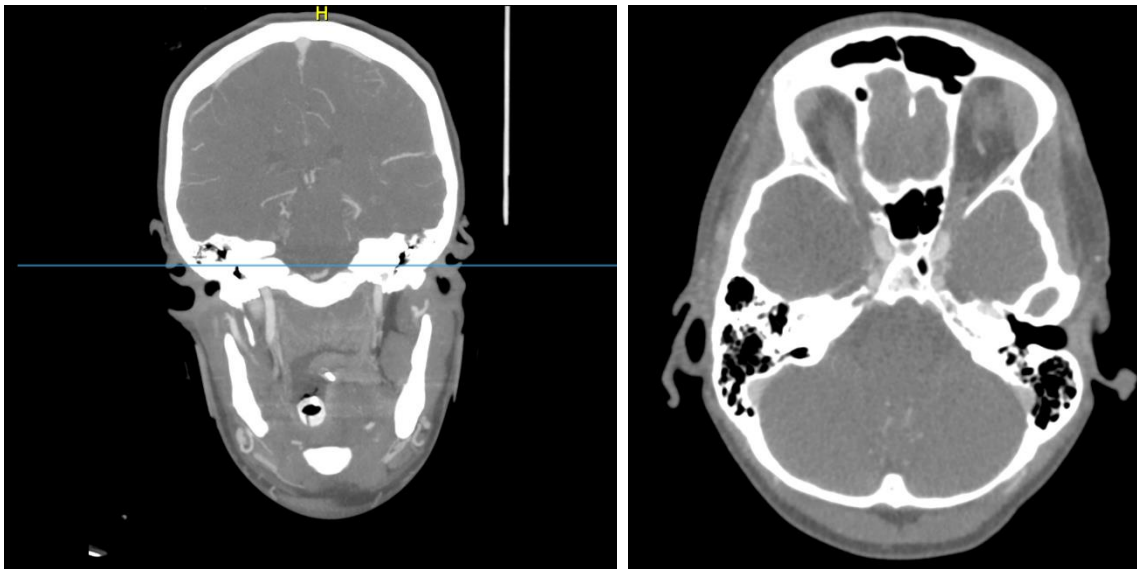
Head CT showing the basilar occlusion on both coronal and axial cuts
